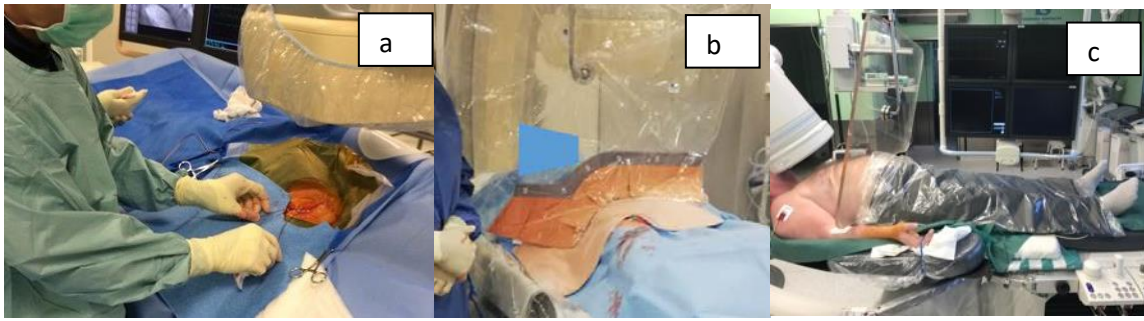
Pictures of two commercially available lead-free drape models: (a) RADPAD subclavian shield (left, Worldwide Innovations & Technologies; source: www.radpad.com), (b) radial X-ray protection drape (right; MAVIG; source: (McCutcheon *et al.*, 2020)) and (c) lead drape of 0.5mmPb and size of 80x100cm (LITE TECH, INC., USA).
